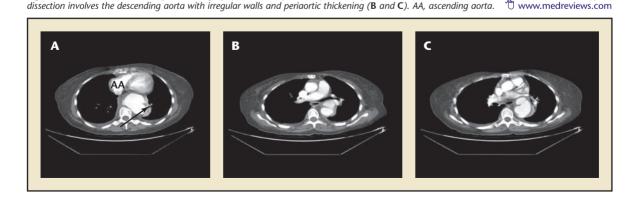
Contrast-enhanced computed tomography scan. Multiple aneurysms with periaortic fibrosis and inflammation are evident (A). The type B
